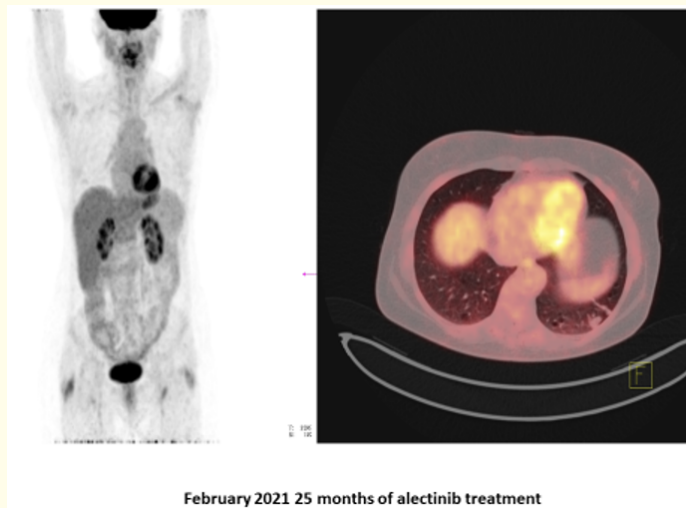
CR at the same patient after 25 months of treatment with alectinib-PET/CT.
